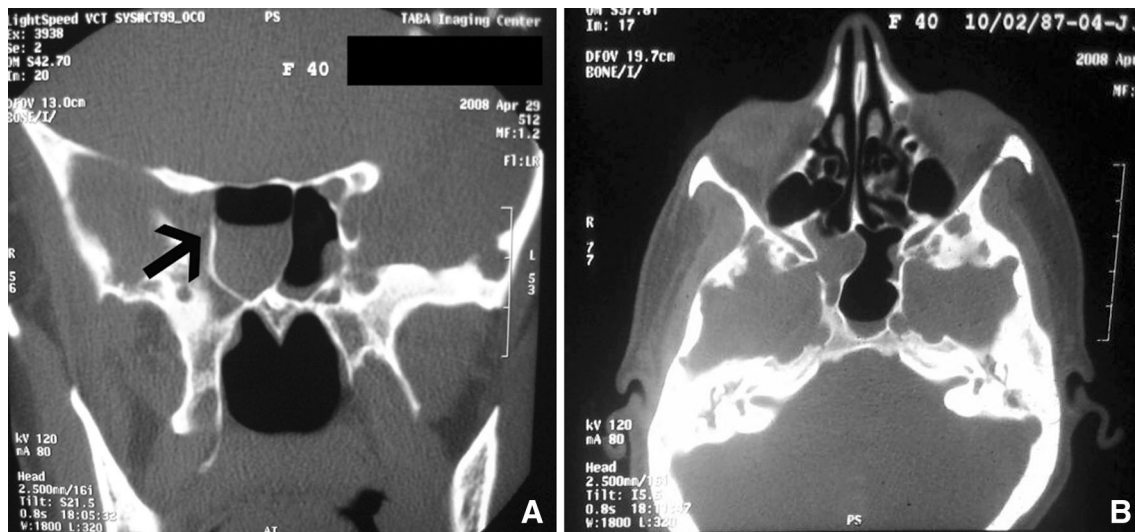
Panel A and B CT scan shows an air-fluid level in the right sphenoid sinus with a small bony defect (*arrow*) in the lateral wall of the right sphenoid sinus
